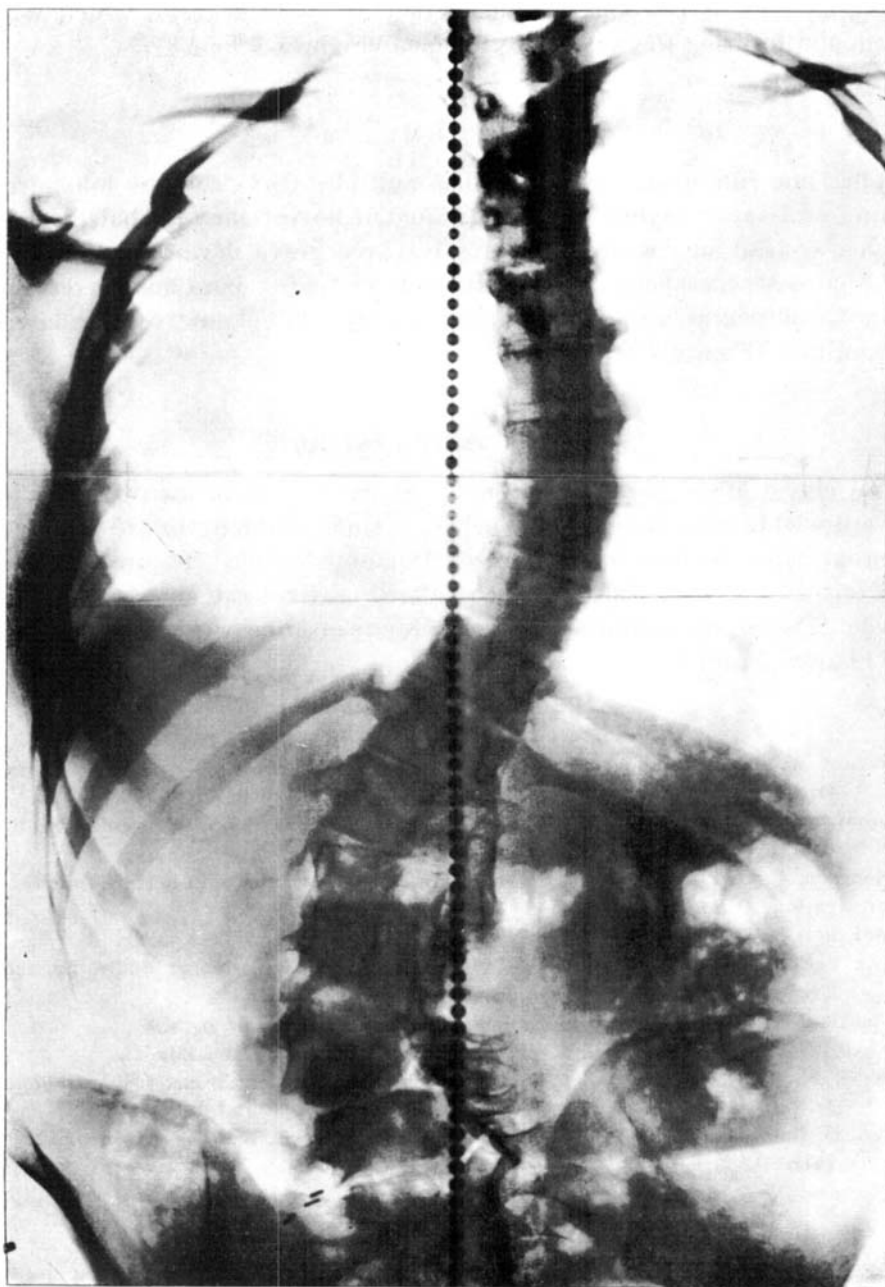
Radiograph of the spine taken in a standing position six and a half years after operations on the cleft vertebra.
